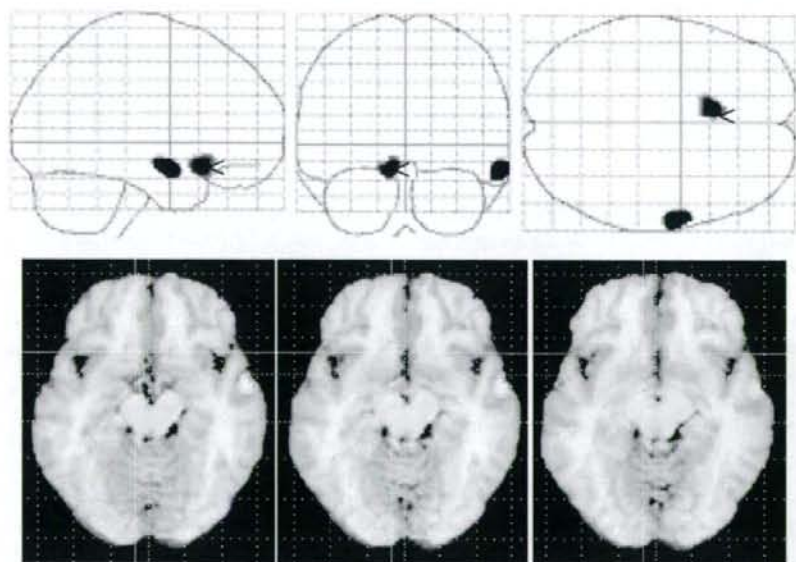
The result of comparison between individuals homozygous for the Val-COMT allele ($n = 57$) and Met-COMT carriers ($n = 66$) (genotype effects). *Top:* Representation in stereotaxic space of regions with significant reduction of volume in individuals homozygous for the Val-COMT allele demonstrated. *Bottom:* The SPM (t) is displayed onto axial T_1 -weighted MR images. Individuals homozygous for the Val-COMT allele demonstrated a significant reduction of volumes in the left ACC and right MTG as compared to Met-COMT carriers.
